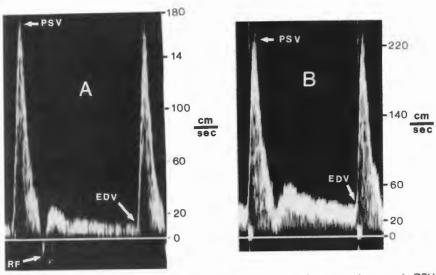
A*, Preprandial and *B*, postprandial SMA waveforms showing an increase in PSV from 180 to 230 cm/s and an increase in EDV from 15 to 35 cm/s. Note the loss of reverse flow (RF). (*From* Moneta GL, Taylor DC, Helton WS, et al: Duplex ultrasound measurement of postprandial blood flow: Effect of meal composition. Gastroenterology 95:1294–1301, 1988; with permission.)
